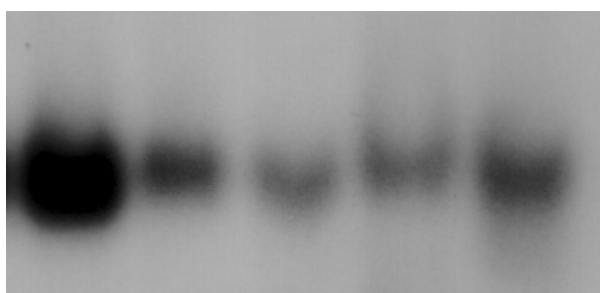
Representative radiographs of HSF-1 activation in PBMCs of healthy controls. Lanes 1-5.
